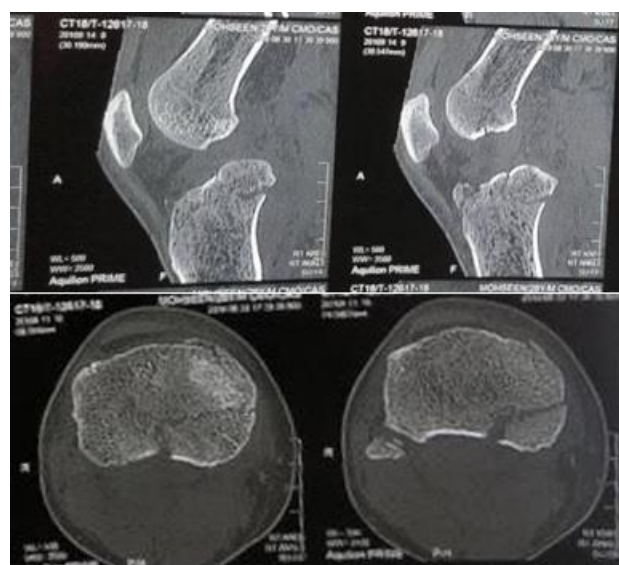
Axial and Sagittal cut of CT scan.
